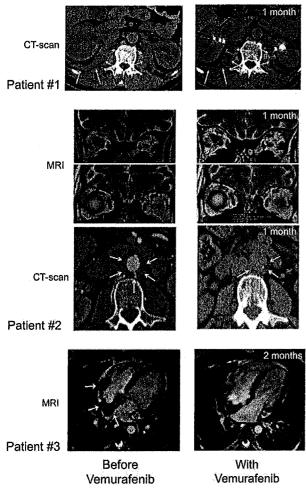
CT scan and MRI imaging assessment. Patient no. 1: Comparison of abdominal axial CT scans performed before (January 28, 2012; left) and on day 37 (May 23, 2012; right) of treatment showing regression of the infiltration around both kidneys (white arrows), evidenced by the decreased thickness (right kidney: 24.8 to 18.2 mm, left kidney 22 to 12.4 mm). Patient no. 2: Comparison of MRI performed before (left) and on day 36 (right) of vemurafenib treatment showing regression of ECD orbital infiltration. Comparison of abdominal axial CT scans performed before (March 29, 2012; left) and on day 39 (May 25, 2012; right) of vemurafenib treatment showing regression of the infiltration around abdominal aorta (white arrows): latero-aortic infiltration from 10.8 to 6.5 mm thick, and posterior infiltration from 6.5 to 4.6 mm thick. Patient no. 3: comparison of cardiac MRI, 4-chamber view: (A) February 21, 2012; see the infiltration of the atrial septum, the posterior wall and the free wall of the right atrium (white arrows); (B) July 19, 2012; note the regression of the infiltration.
